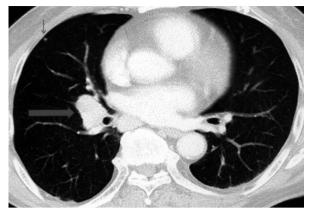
Chest CT revealed a soft tissue mass at the right lower lung (big arrow) and a nodule in the right lower lung (small arrow)
